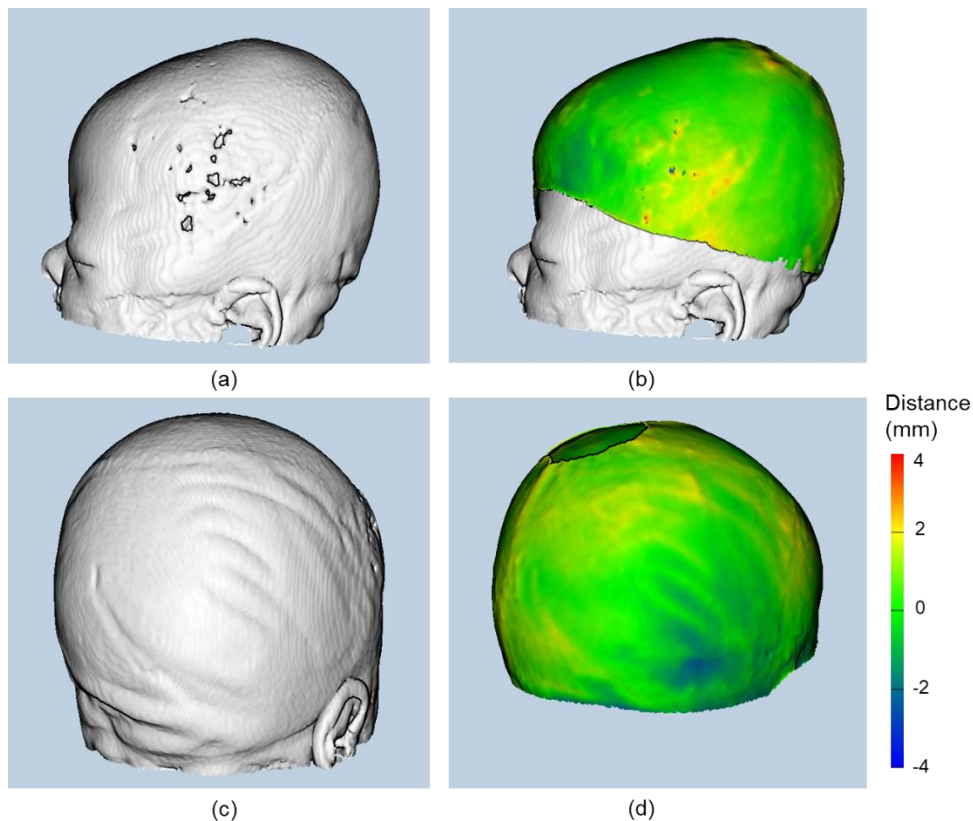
Examples of errors found in MRI 3D models due to holes (a) and lying position of the patient during the data acquisition (c). These errors affect the distance differences between photogrammetry and MRI (b, d), respectively.
